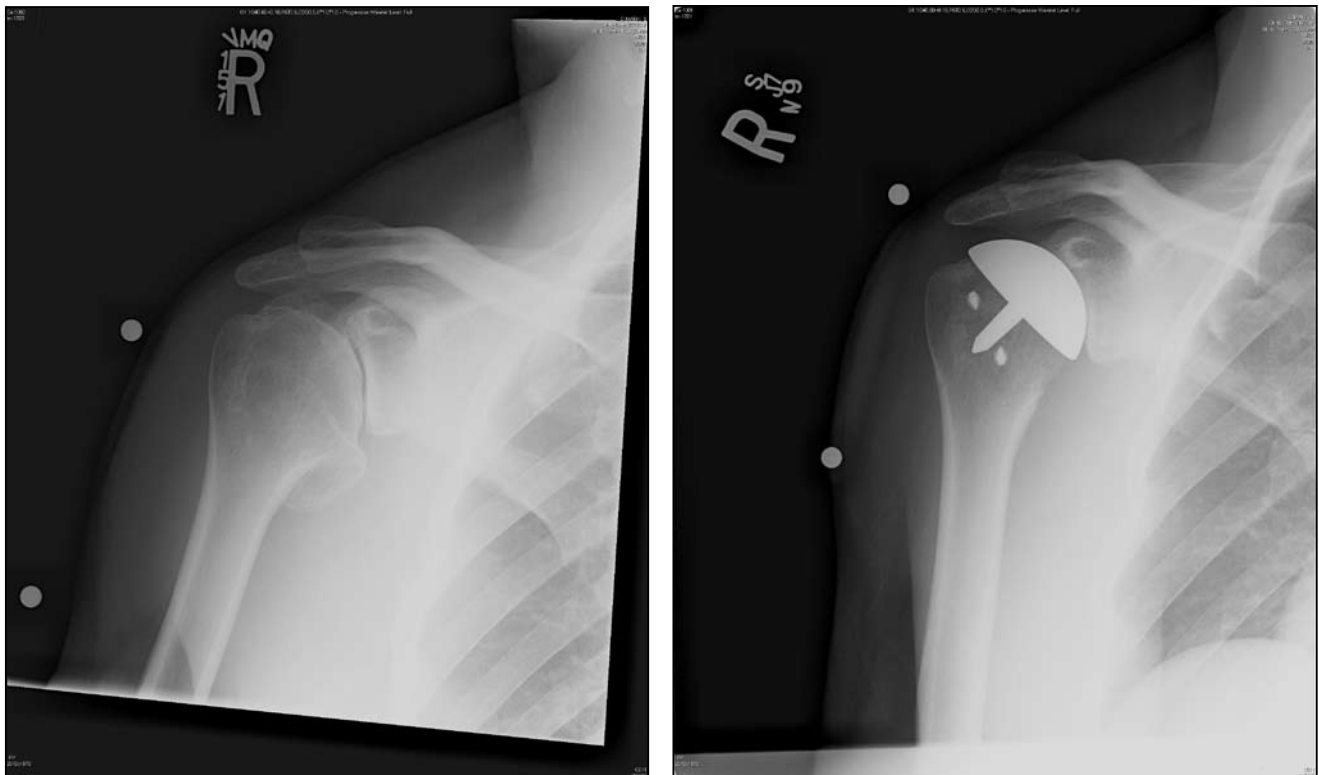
(left) and b (right). (a) True anterior posterior plain radiograph of a 43 year active male with pain who failed previous arthroscopic surgery. (b) Post-operative radiograph after humeral resurfacing.
